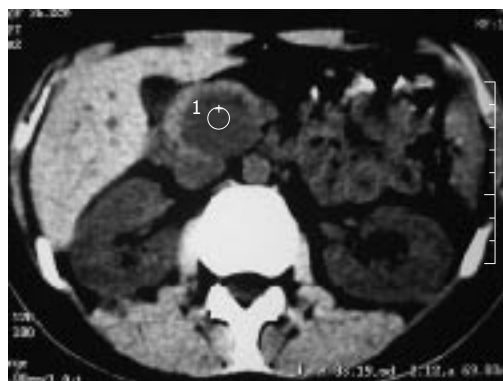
Axial precontrast CT image shows that the mass is hypodense with no evidence of calcification. The density of the mass is measured 38.19 HU.
